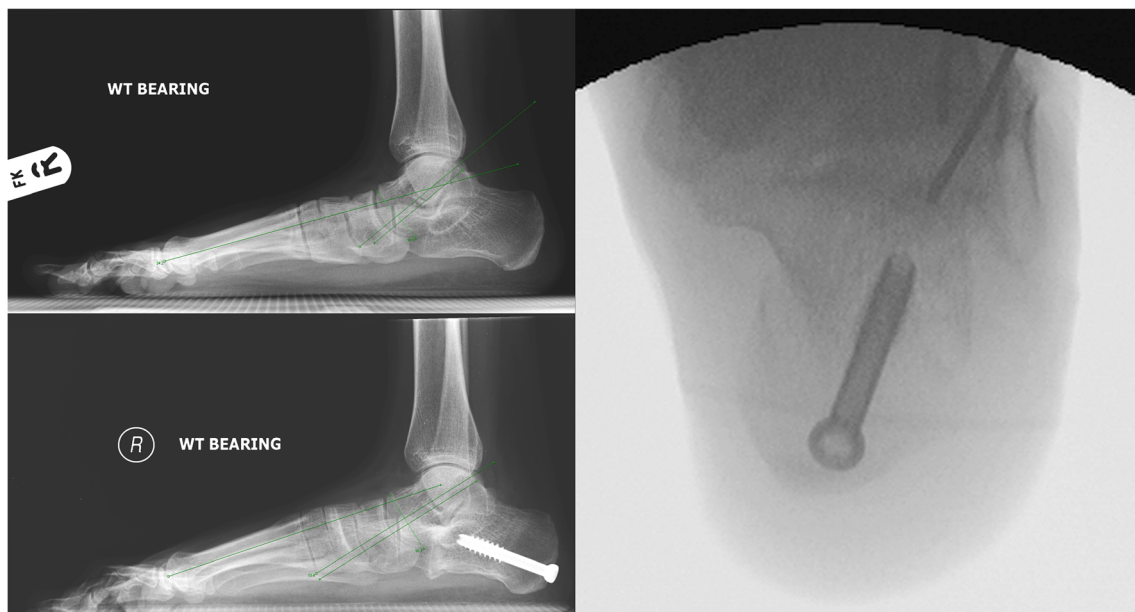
Patient A1. Top left, pre-operative weight-bearing lateral foot X-ray showing Meary's angle of -24.20° . Bottom left, post correction weight-bearing lateral foot X-ray showing Meary's angle of -13.40° (10.80°
